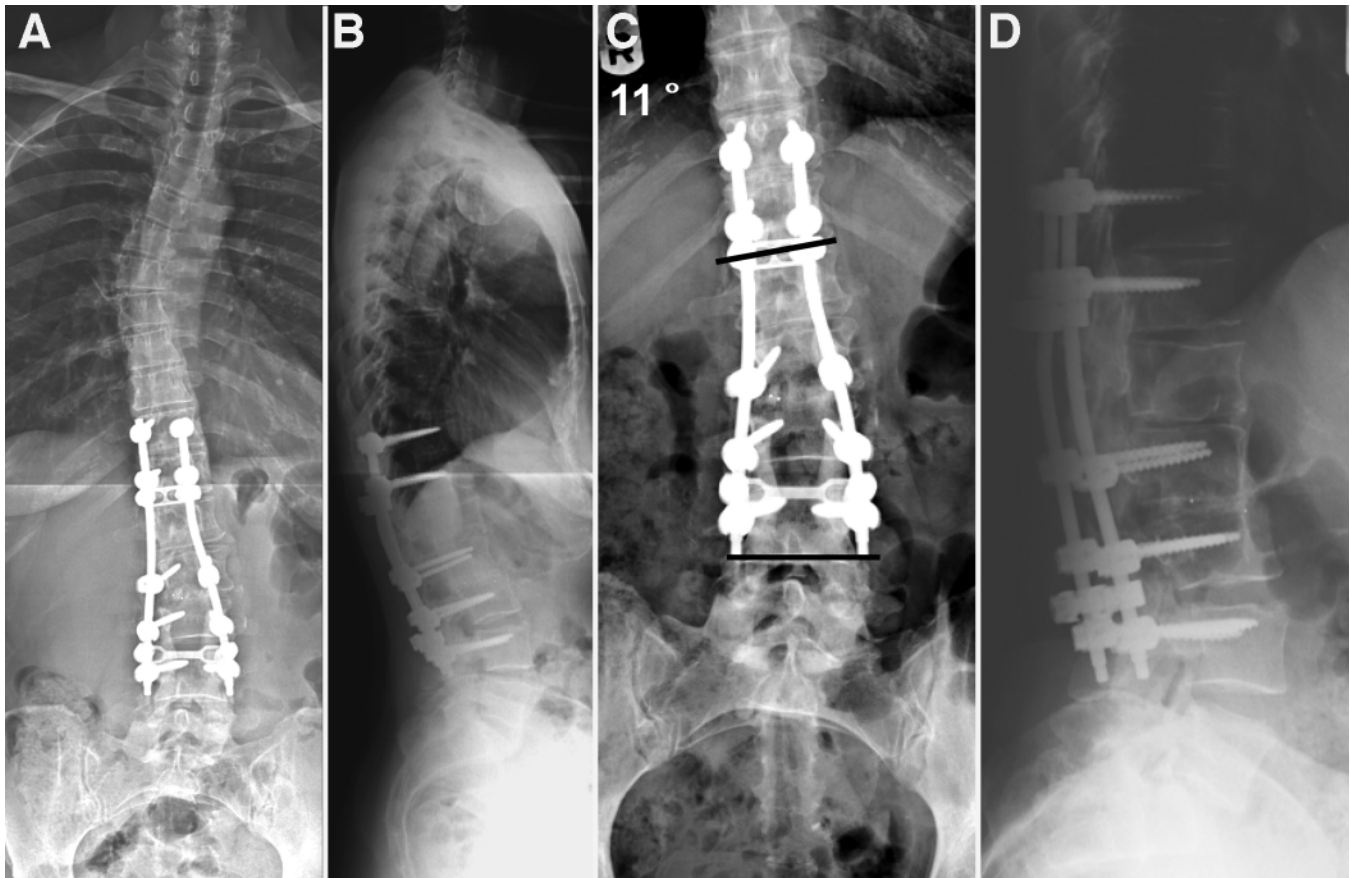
Case 4. Postoperative 36-inch standing anterolateral and lateral radiographs (A and B) and lumbar spine AP and lateral radiographs (C and D) following a posterolateral instrumented T11–L4 fusion and placement of a single unilateral interbody cage at the right L2–3 interspace. A coronal plane correction of 15.4° (58%) was achieved with preservation of the global sagittal balance.
